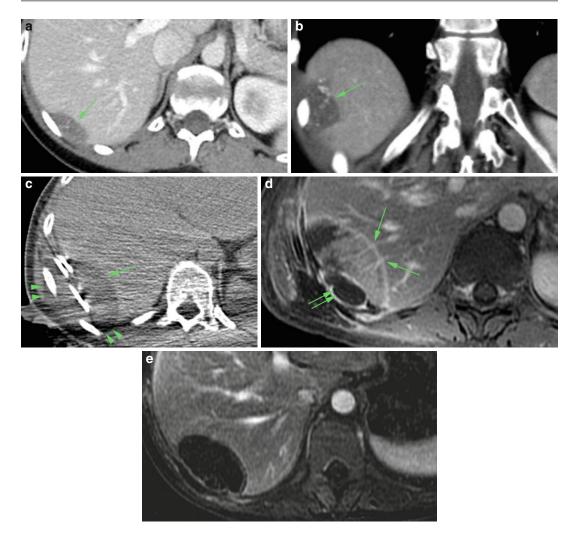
A 50-year-old woman with poorly differentiated mullerian carcinoma of the peritoneum diagnosed 2 years earlier. She presented following surgical resection of recurrent pelvic tumor for cryoablation of a perihepatic metastasis situated between the right hepatic lobe and the lower right hemidiaphragm. (a) Contrast-enhanced axial CT image demonstrates the tumor, measuring 1.5 cm by 3.7 cm. (b) A coronal CT image reveals calcification within the tumor and a cranio-caudal dimension of 3.7 cm. (c) Noncontrast CT during the cryoablation procedure demonstrates extension of the iceball into the liver medially (*arrow*) and the body wall laterally (*arrow heads*), ensuring adequate margins around the peritoneal metastasis. (d)
